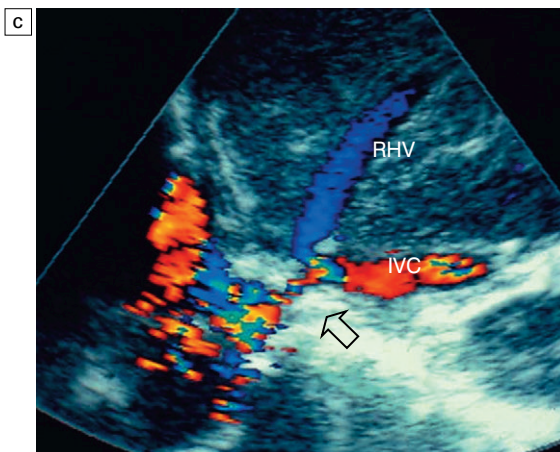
(a) Colour Doppler image of the hepatic vein confluence with the IVC. Note the relatively distended hepatic veins and the colour aliasing at the anastomosis. (b) Spectral Doppler tracing of the middle hepatic vein shows complete absence of periodicity. Since this tracing is acquired within a few centimetres of the heart, one should expect to see normal hepatic vein flow periodicity. Its absence indicates hepatic venous outflow obstruction either due to organ shift and kinking or stenosis due to fibrosis. (c) A longitudinal colour Doppler image at the junction of the right hepatic vein (RHV) and inferior vena cava (IVC) shows a distended hepatic vein with flow backed up behind a focal stenosis (arrow).
